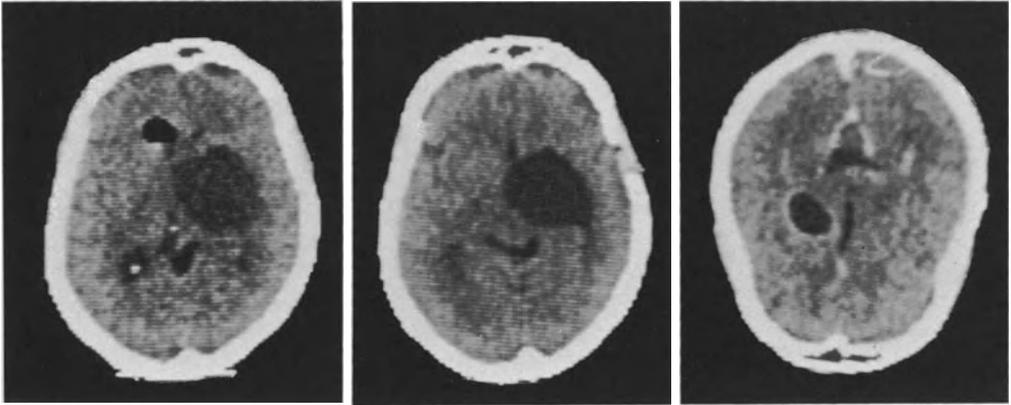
CT-controls of a craniopharyngioma-cyst, treated by instillation of Yttrium-90. *Left upper cut:* Preoperative state. *Right upper cut:* State 14 days after operation. *Lower cut:* State 6 months after operation. Note the gradual shrinkage of the cyst
